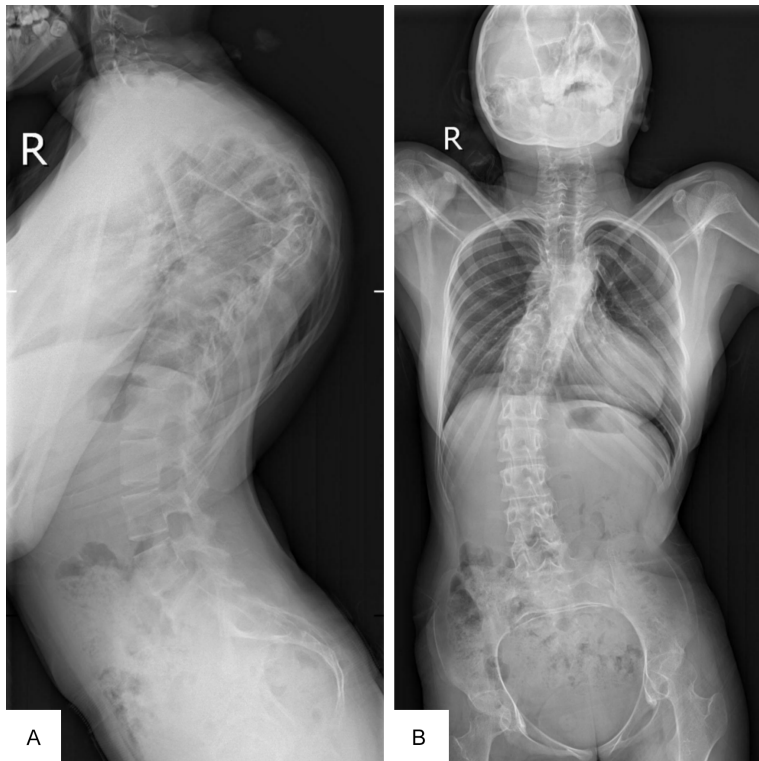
A: Lateral position X-ray image showing kyphosis curvature greater than 100 degrees from T1 to T12. B: Anteroposterior position X-ray showing that the scoliosis had a Cobb angle of 36 degrees from T1 to T12.
